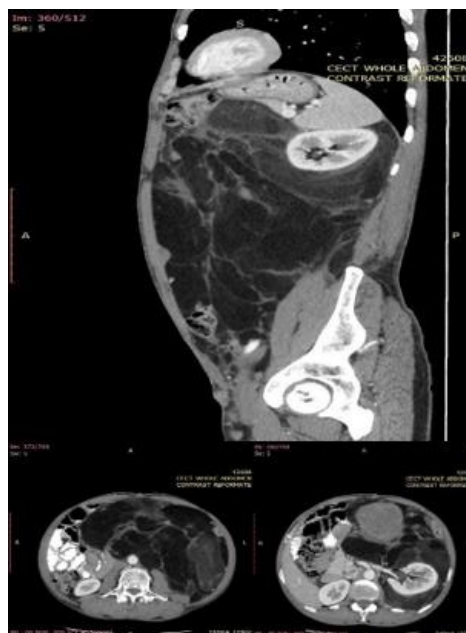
Pre- Op Contrast Enhanced Computed Tomography Whole Abdomen
